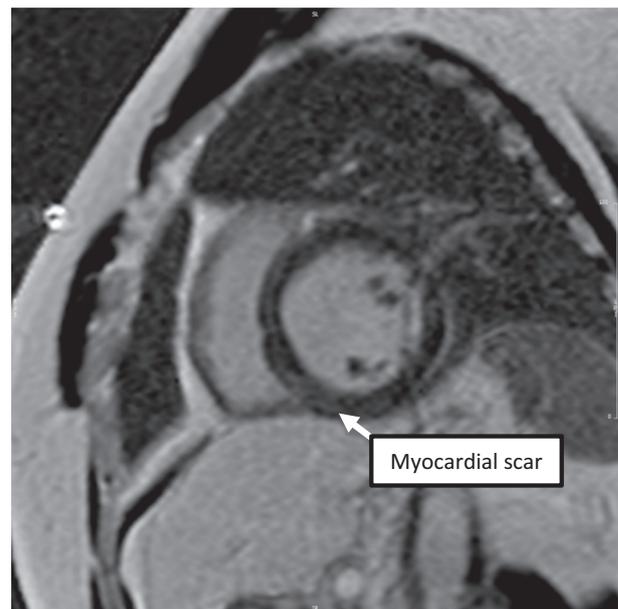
Cardiac magnetic resonance imaging with delayed gadolinium-enhancement. There is mid myocardial delayed gadolinium enhancement in the ventricular septum in the basal and mid ventricle, consistent with myocardial midwall fibrosis (MWF). MWF has been linked to arrhythmic risk in nonischemic cardiomyopathy.
